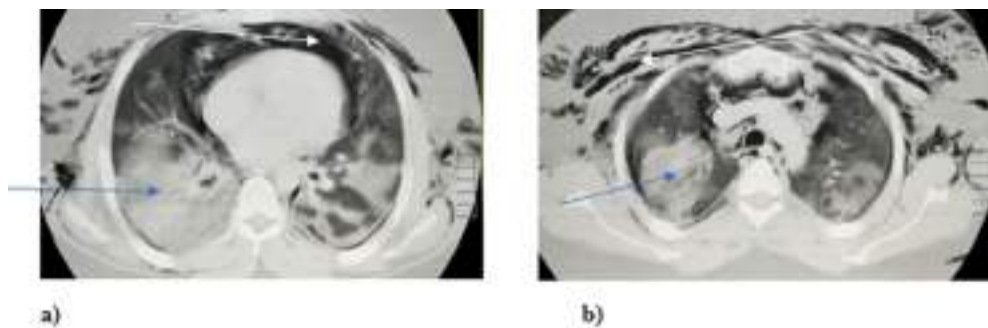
On 12th day of the event in CT scan of lung was seen: (c) minimal Pneumomediastinum and (d) consolidation ground glass opacity.
